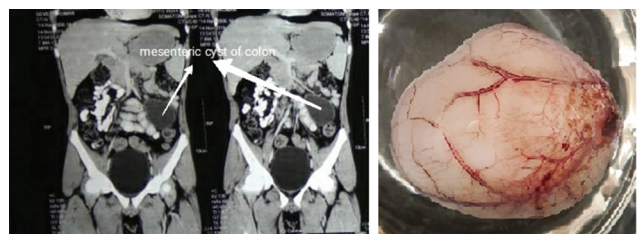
CT scan abdomen of a 6-month-old male patient with left ileac fossa mass showing colonic cyst; laparotomy with excision of cyst was done.
